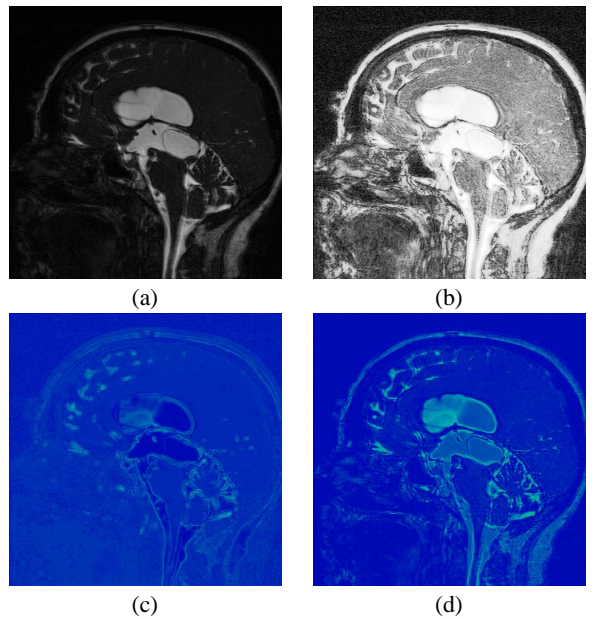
Other windowing operator applied to the MRI CISS dataset. (a) Original image slice, (b) histogram equalized image slice with increased background noise. (c) Absolute intensity difference between VHDR windowing (Fig. 6e) and after Ashikhmin’s tone reproduction operator and (d) Durand’s bilateral filtering.
